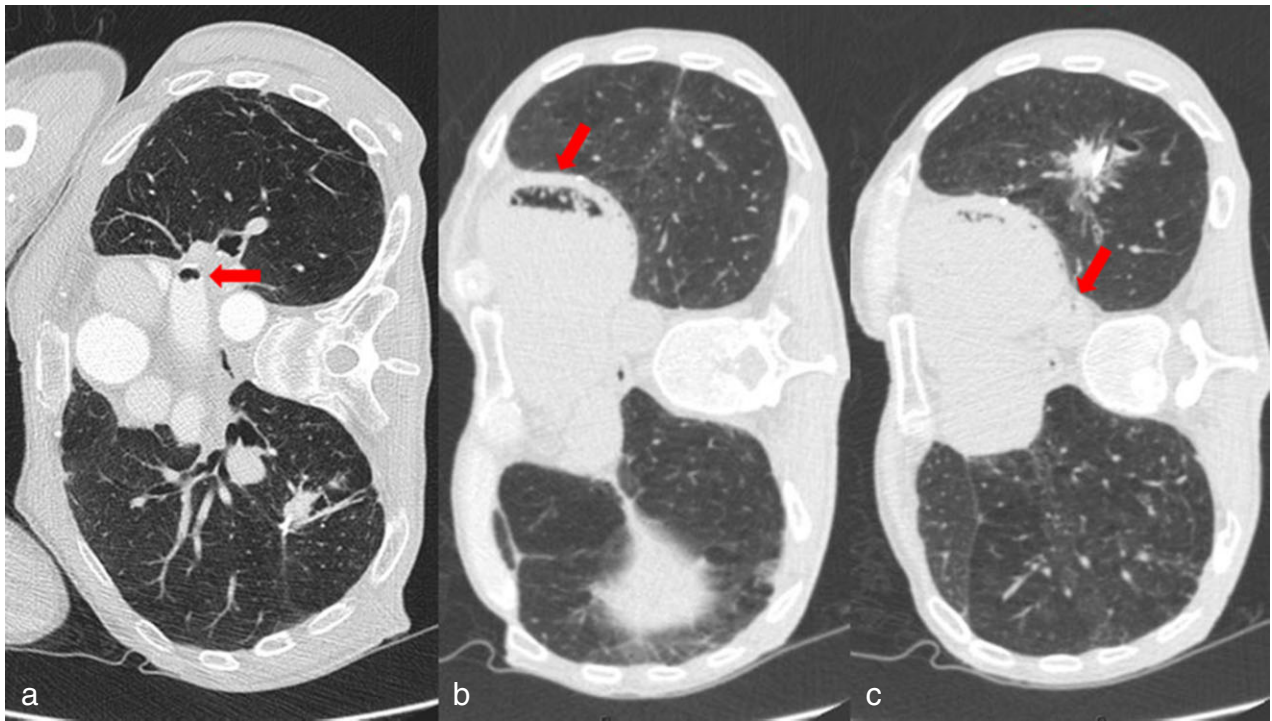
(a) Post-procedural chest computed tomography demonstrating air blebs in the left pulmonary vein, (b) with subsequent scans showing migration to the left ventricle, (c) and to the descending aorta.
